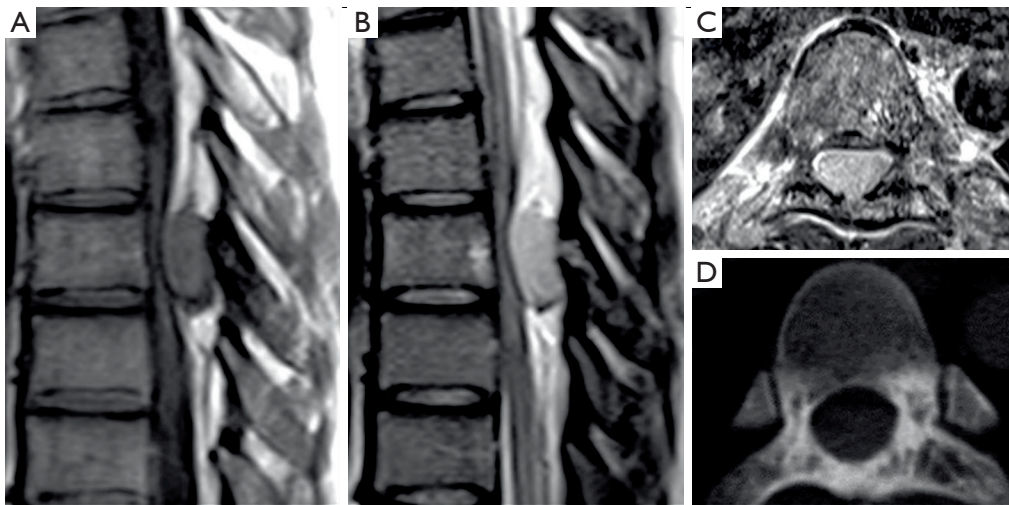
The pre-operative magnetic resonance image (MRI) demonstrated an enlarged mass, causing spinal cord compression, which had isointensity on the T1-weighted image (A), hyperintensity on the T2-weighted image (B) and a strong enhancement on the T1-weighted image (C). Atypical reactive sclerotic change was noticed on the pre-operative computed tomography scans (D).
